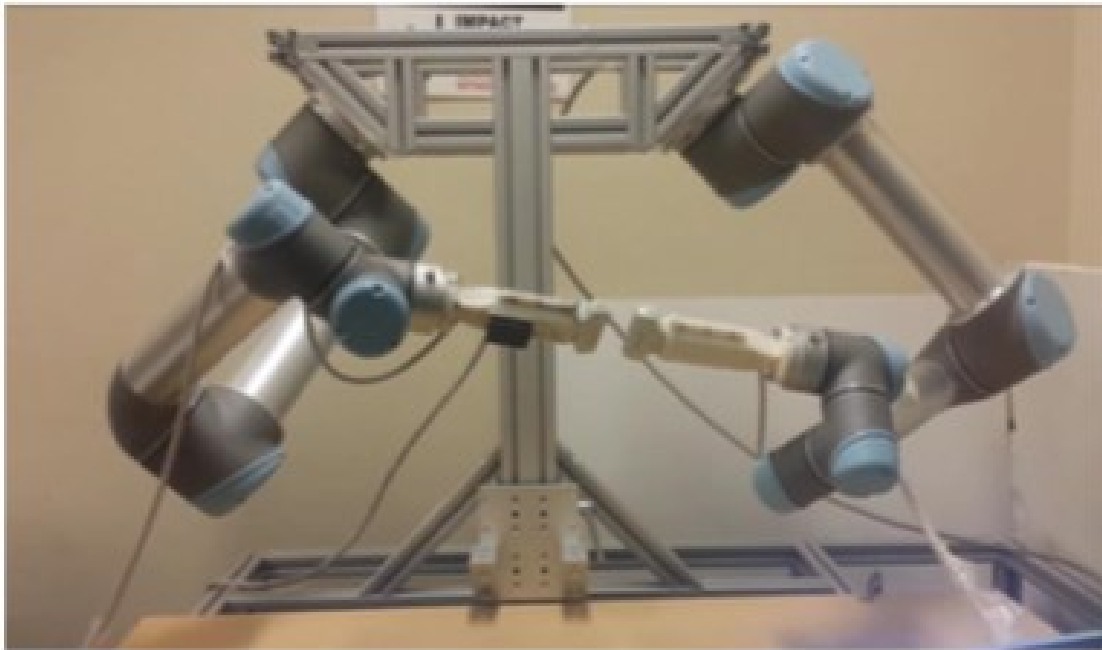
Dual arm robotic ultrasound system for ultrasound tomography [32]. Reprinted with permission from SPIE ©2015 SPIE.
